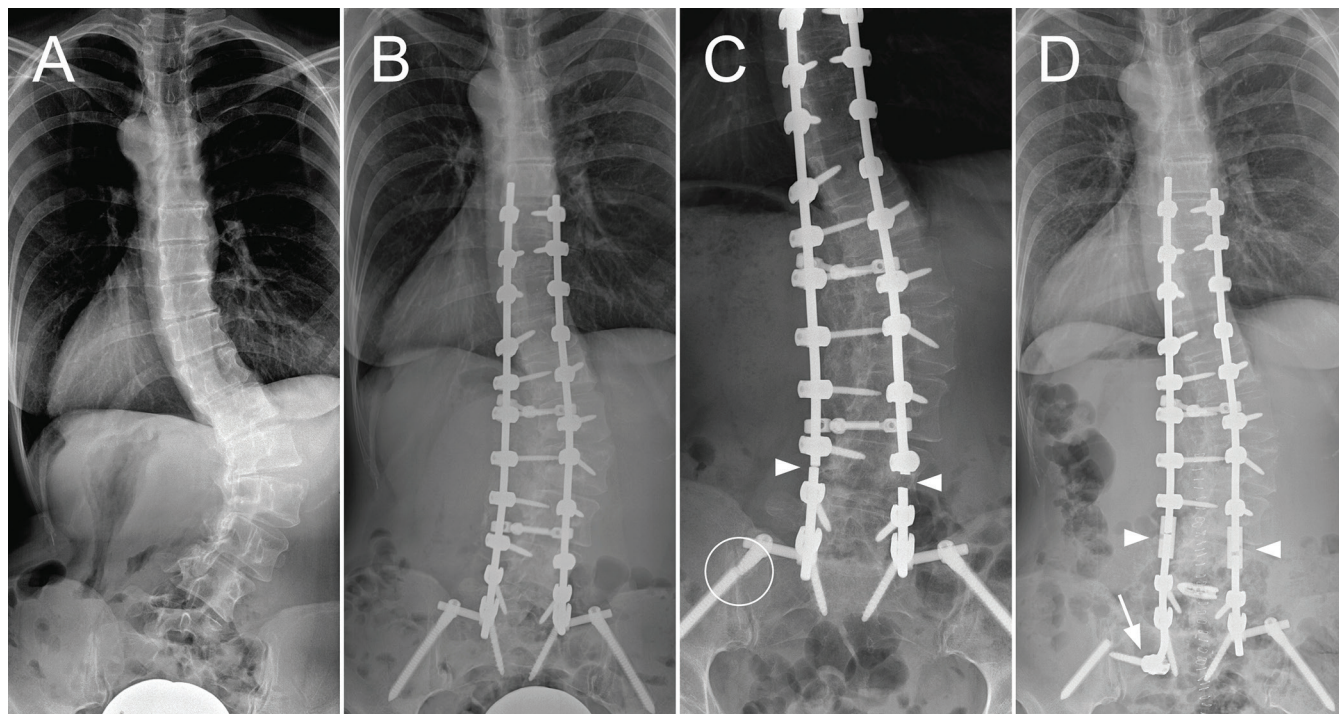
Revision Case No. 1: Anteroposterior radiographs of the patient's spine before (A) and after surgery (B). C – the condition after the breakage of the left and right fixation rods (arrowheads) and the breakage of the left iliac screw (circled). D – connection of the broken rods with a connecting link (arrowheads), removal of the proximal part of the iliac screw and fixation of the distal part of the left rod into the sacrum with a sacral-alar screw (arrow).
